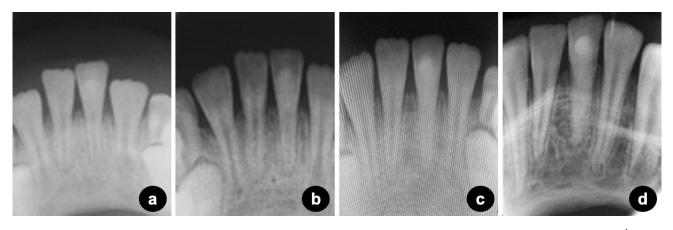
a:3-month follow-up radiograph. b: 6-months follow-up radiograph. c: At the 12-months follow-up, apical closure was evident. d: At the 24th month, pulp canal obliteration at #31 was observed.
